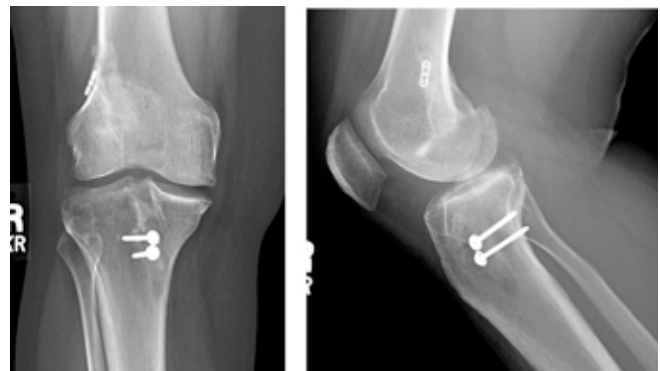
AP and lateral radiographs 3 months after right knee revision ACL reconstruction using screw fixation of the graft within the tibial tunnel. Washers can be used in order to increase the surface area for compression across the graft, as demonstrated in these radiographs.
